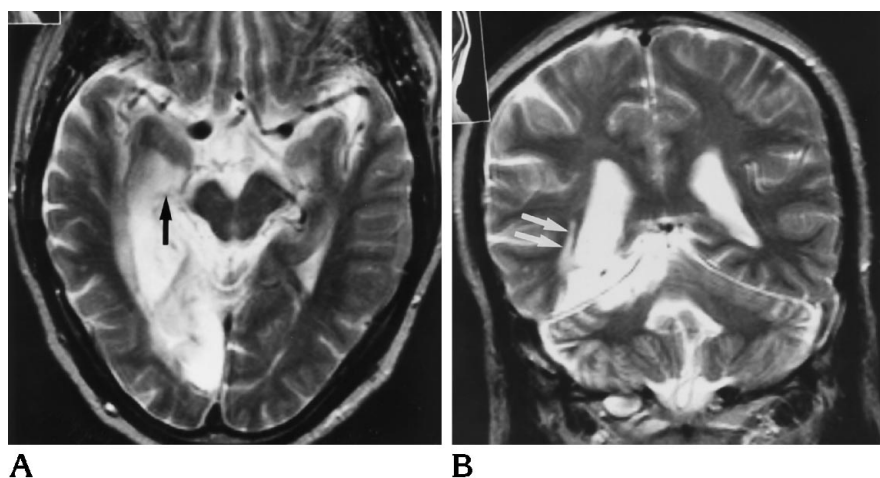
T2-weighted MR images from a 50-year-old man with hemiplegia and hemianopsia due to cerebral infarction.
